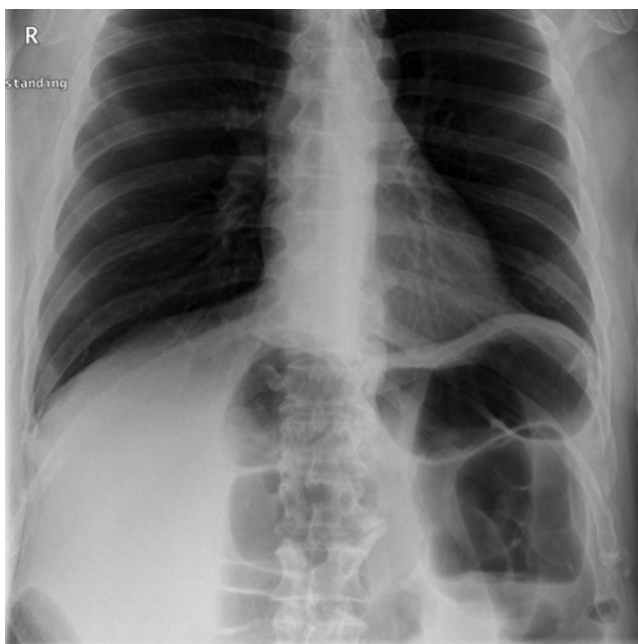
Plain film of patient described in this clinical scenario. Distended loops of large bowel are concerning for a distal large bowel obstruction.
